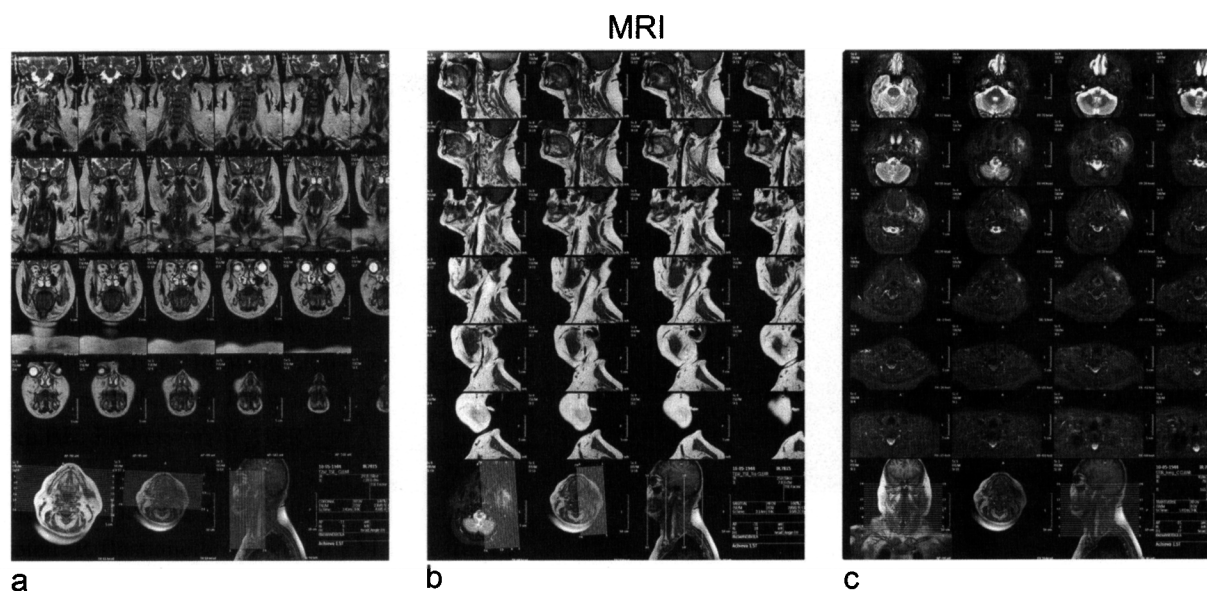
Magnetic Resonance (MR) images show a high signal intensity related to osteonecrosis. *a)* T2 weighted MR images show a high signal in the left side of the jaw (*b, c*) T1 weighted MR and short tau inversion recover (STIR) images show soft tissue enhancement surrounding the left mandible that is related to the presence of oedema.
